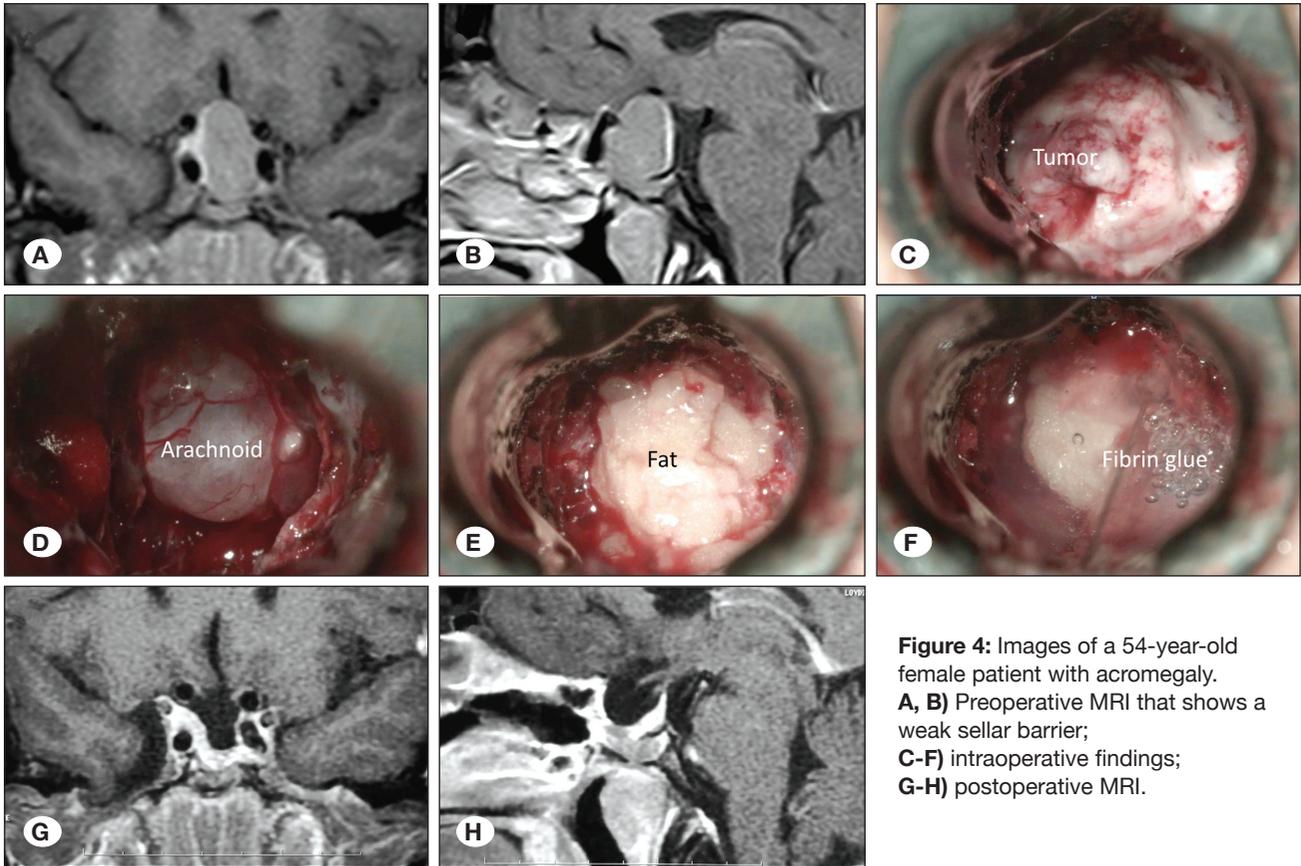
Images of a 54-year-old female patient with acromegaly. A, B) Preoperative MRI that shows a weak sellar barrier; C-F) intraoperative findings; G-H) postoperative MRI.
